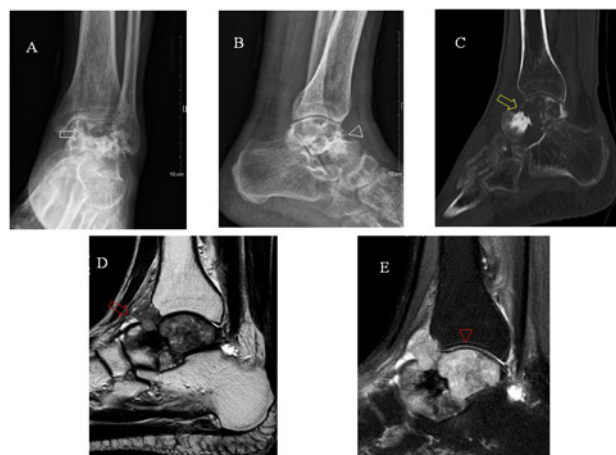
Anteroposterior (A) and lateral (B) radiographs of the left ankle demonstrated collapse of the left talus with patchy high intensity shadow and narrowing of the left tibial astragaloid joint space (white arrow and arrowhead). Computed Tomography (CT) of the left ankle showed collapse of the left talus with discontinuous cortex, large patch of low intensity region with patchy high intensity shadow, and narrowing of the left tibial astragaloid joint space (C, yellow arrow). Magnetic Resonance Imaging (MRI) revealed wide destruction of the left talus with collapse, soft-tissue in the left talus, which grew toward the anterior aspect of the left ankle. The signal intensity was low on T1-weighted images (D, red arrow), high on fat-suppressed images with moderate contrast enhancement (E, red arrowhead).
